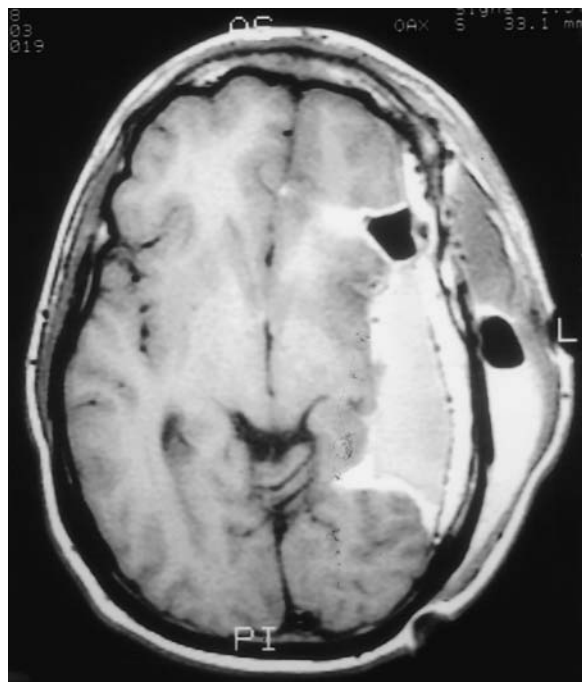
Postoperative axial T1 MRI following left ultrasound-guided hemispherectomy in an 11-year-old girl. Large subcutaneous fluid collections, disconnection of the frontal and occipital polar cortices, and broad central topectomy are present.
